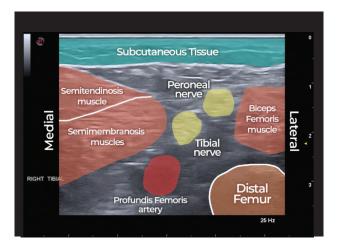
Transverse ultrasound of the popliteal fossa.
